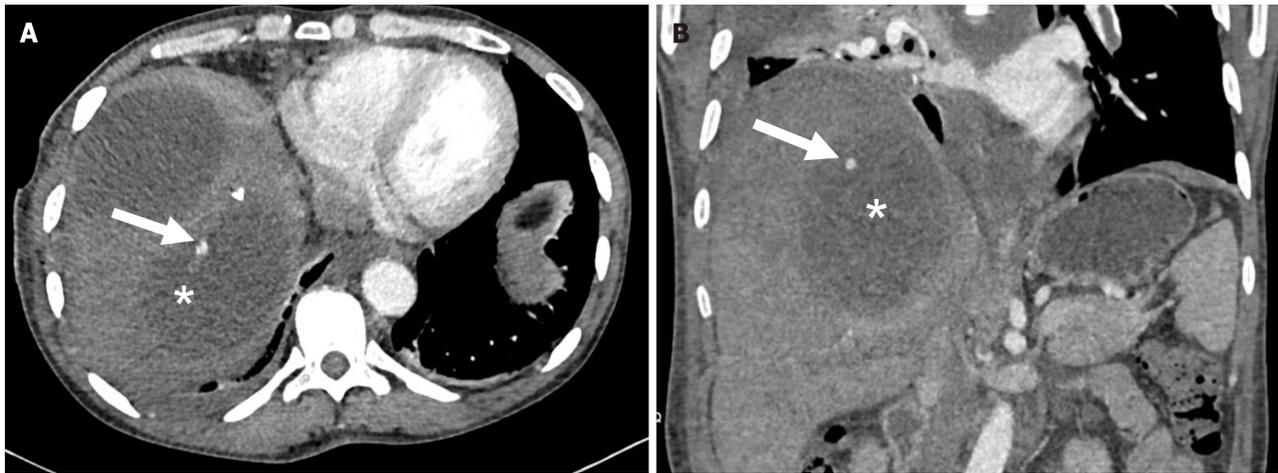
Computed tomography scan image of hepatic artery pseudoaneurysm in association with liver abscess. A: Axial image demonstrating a small aneurysm (arrow) originating from a peripheral branch of the right hepatic artery within the abscess cavity (asterisk); B: Coronal computed tomography image of the same patient demonstrating the hepatic artery pseudoaneurysm.
